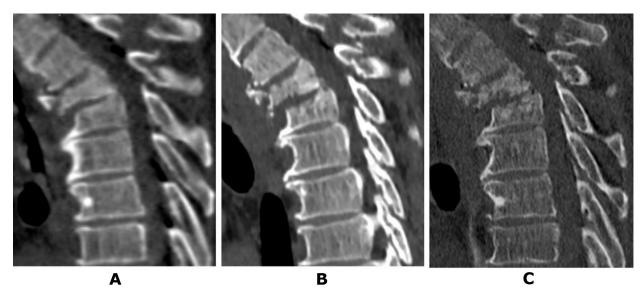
Patient N., 50 years old. CT scans of the thoracic spine: A – on the day of the injury; B – after 2 weeks; C – after 1 month (details in the text)
